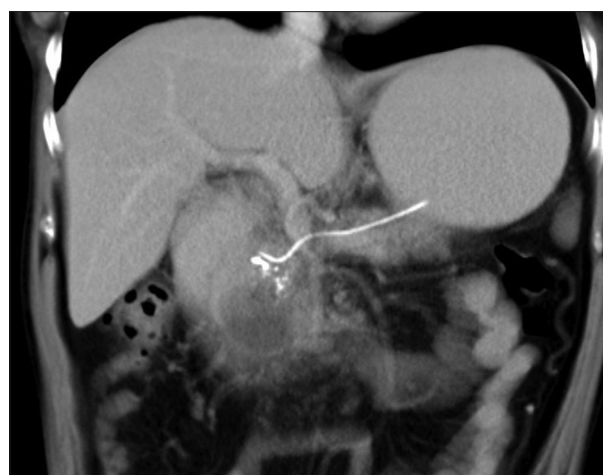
Computed tomography abdomen: pancreatico-gastrostomy stent seen *in situ* with decompressed main pancreatic duct. The stones at the neck of the pancreas can be seen adjacent to the distal end of the stent
